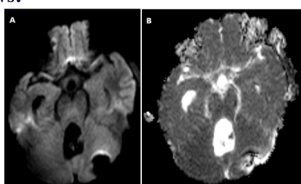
MRI a) DWI, b) ADC, c & d) T2 AXIAL: a & b) No diffusion restriction. c) heterogeneously hyperintense lesion in 4th ventricle d) fat fluid level in frontal horns of bilateral lateral ventricles and Severe hydrocephalus.
